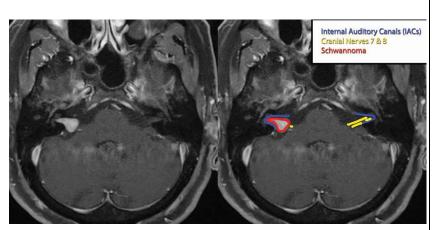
Axial T1 fat saturated MRI sequence post contrast. University of Massachusetts Medical School, Department of Radiology.
